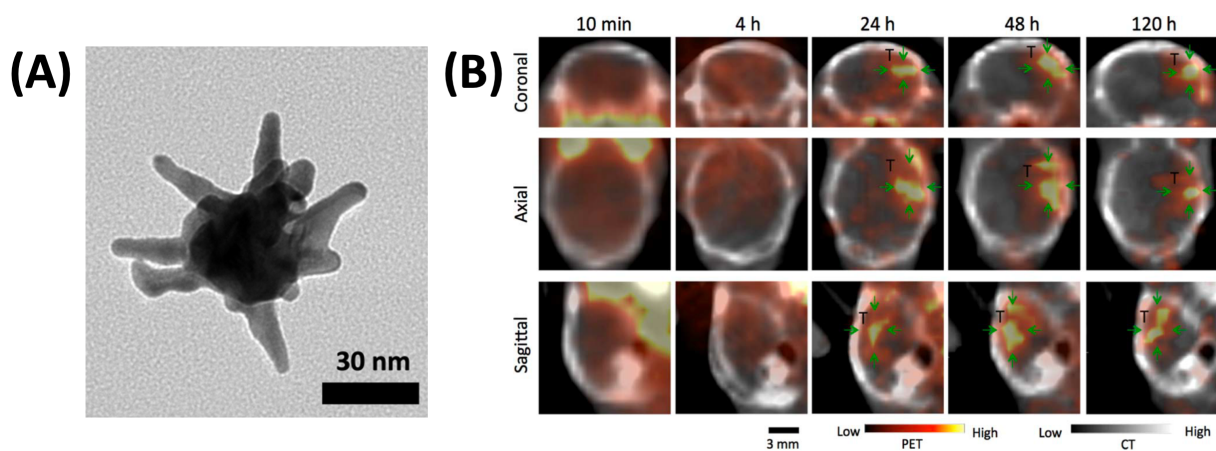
(A) TEM imaging of developed 50-nm star-shaped AuNPs. (B) PET/CT imaging of I-124 labeled star-shape AuNPs in the intracranial brain tumor 10 min, 4 h, 24 h, 48 h, and 120 h after intravenous injection. Top, middle and bottom rows show coronal, axial and sagittal image, respectively. Significantly higher ^{124}I -AuNPs uptake in tumor (T; green arrows) compared with contralateral normal brain was observed at 24 h.
